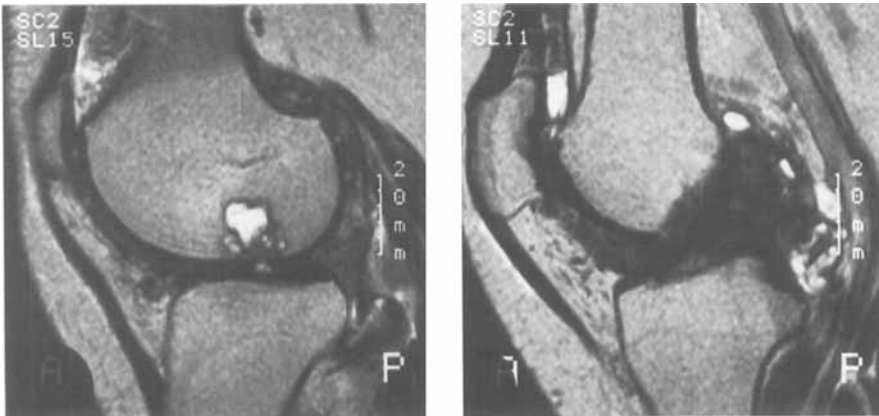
Case 1. T2-weighted MRI showing a fluid-containing cystic lesion in the lateral femoral condyle (left) and synovial masses posteriorly in the joint with low signal intensity indicating hemosiderin deposition (right).
